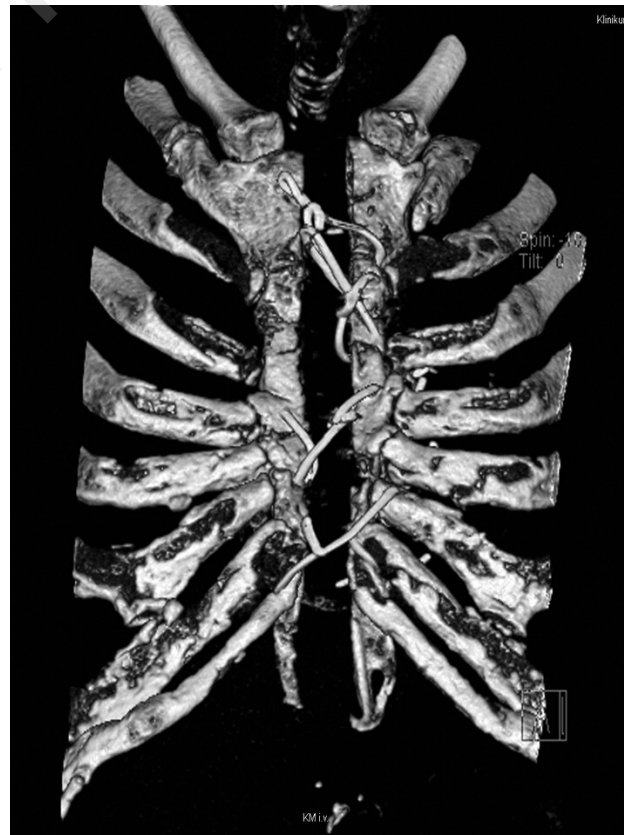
Chest computed tomography scan with color-coded three-dimensional reconstruction (anterior view) after the episode of intense coughing.
